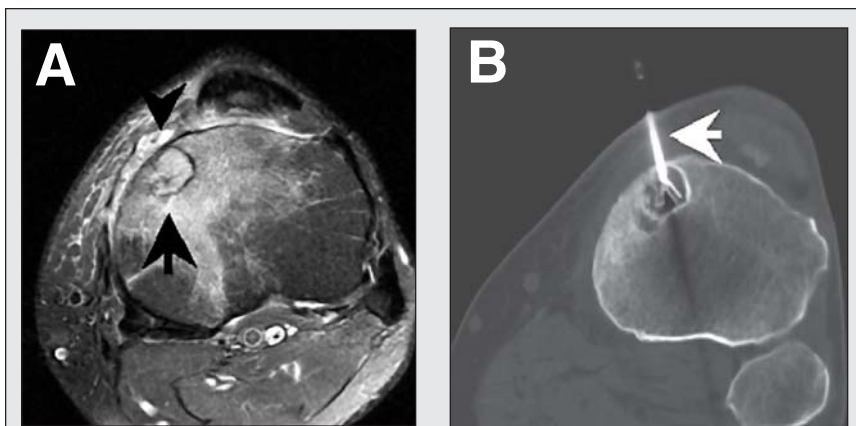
RF Electrode Placement—(A) Fat-suppressed T2-weighted axial magnetic resonance image of upper tibia and fibula. Metastatic malignant melanoma lesion contained within the tibia (arrow) with surrounding bony edema. Metastatic melanoma is also present in soft tissues overlying the anterior aspect of the tibia (arrowhead). (B) Axial CT image at corresponding level with RF electrode (arrow) placed within the osteolytic metastatic tumor. CT = computed tomography; RF = radiofrequency.
